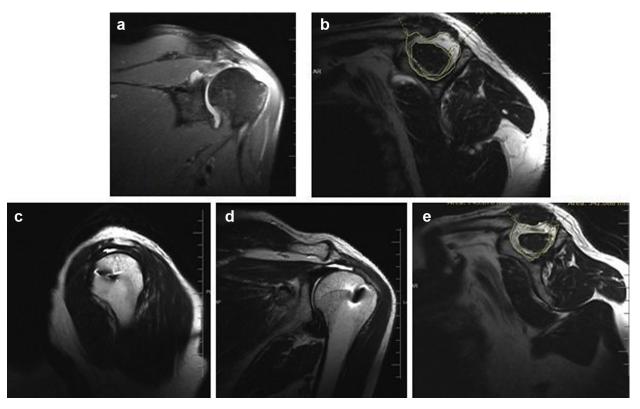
A 58-year-old male patient with an atraumatic chronic rotator cuff tear. (a) A large-sized supraspinatus tear was noted on the preoperative, coronal magnetic resonance imaging (MRI) scan. (b) Preoperative Goutallier grade 2 fatty infiltration and occupancy ratio of 0.40 in sagittal Y view. (c, d) Final follow-up showed type 4 repair integrity as per Sugaya classification, that is, retear of the supraspinatus in sagittal and coronal view of MRI. (e) The occupancy ratio diminished from 0.40 to 0.35, with increased fatty infiltration from preoperation to 12-month follow-up.
